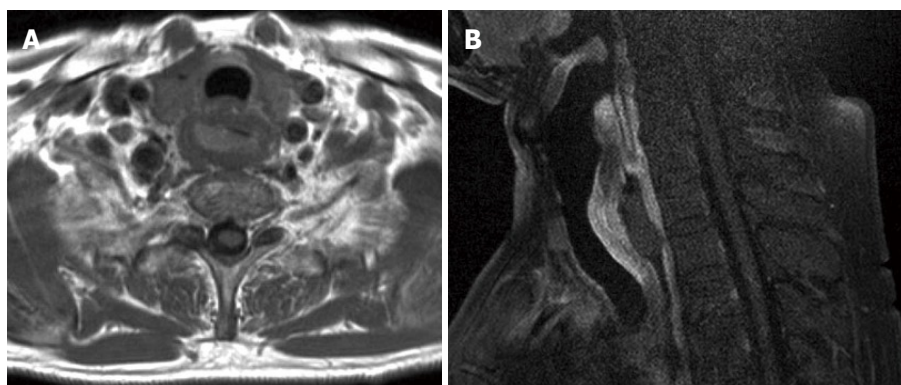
Magnetic resonance imaging (MRI) findings. A: Chest T1-weighted MRI, transverse section. Circumferential wall thickening is seen in the cervical esophagus; B: Chest MRI with gadolinium contrast, sagittal section. Esophageal wall thickening extends about 4 cm, and a contrast effect is evident.
